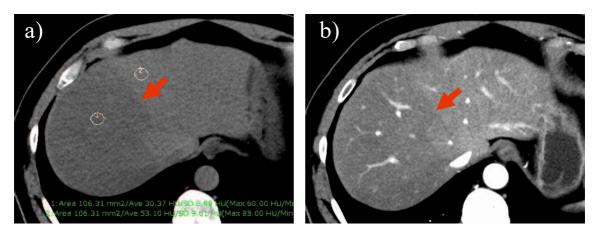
右葉の区域性脂肪肝 (a)単純 CT (b)動脈相 CT
